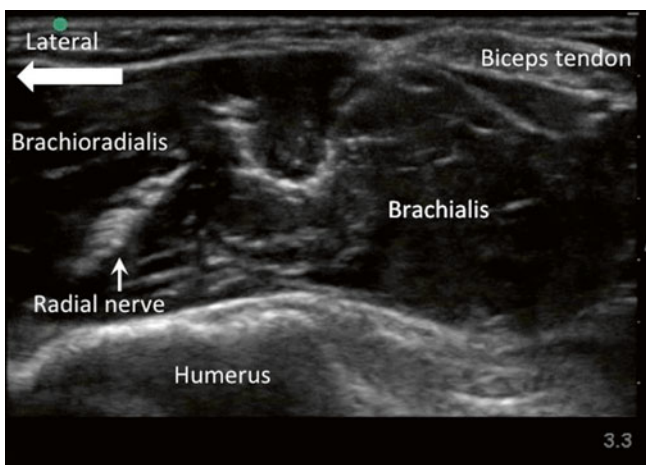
Sonogram of the radial nerve. At the level of lateral epicondyle, the radial nerve is consistently located between the brachioradialis and brachialis muscles (Reproduced with permission from Philip Peng Educational Series)
